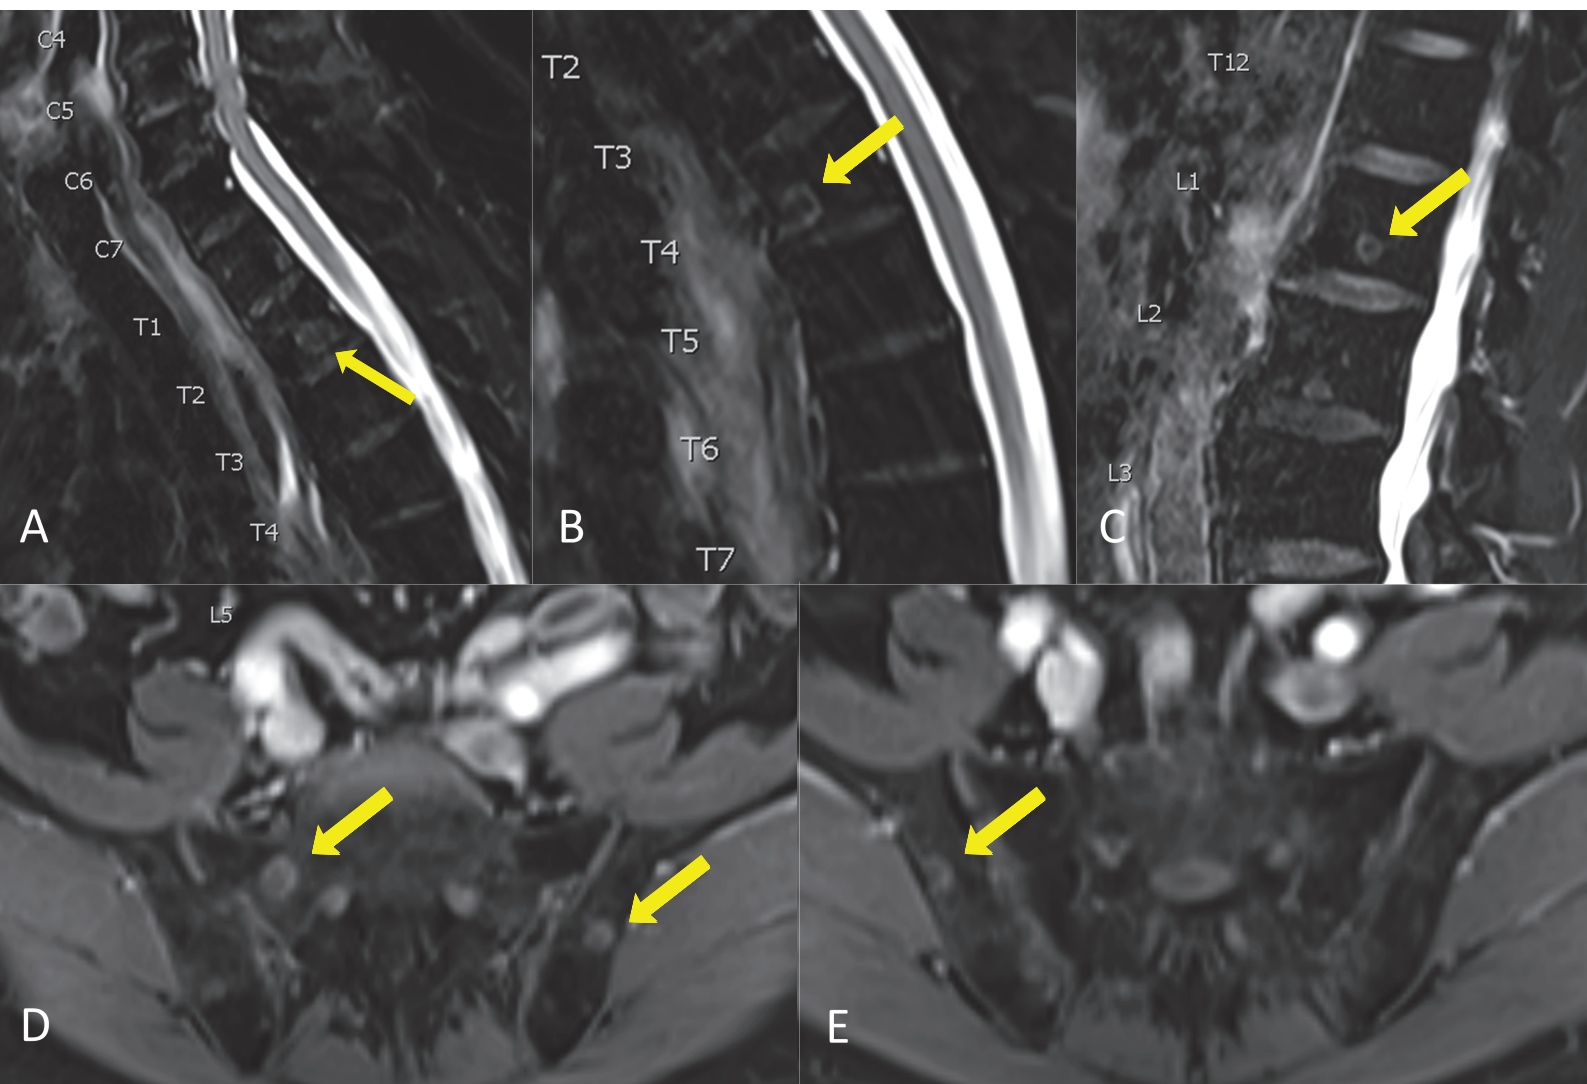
Whole-body magnetic resonance imaging (MRI) sagittal T2-weighted images with fat saturation shows multiple bone metastasis in the vertebral spine (arrows) in A, B and C and in the pelvic bone (arrows) in D and E (axial Dixon T1-weighted images post-contrast) in a 68 y.o. patient with biochemical recurrence of prostate cancer (primary tumour pT2c, GS 4+4=8, 80% PSMA%neg). The patient had three negative ^{68}Ga -PSMA-11-PET scans for biochemical recurrence under PSA levels of 4.65 ng/ml, 20.36 ng/ml and 72 ng/ml with a PSMA-negative suspicious new bone lesion in the sacrum in the latter scan.
